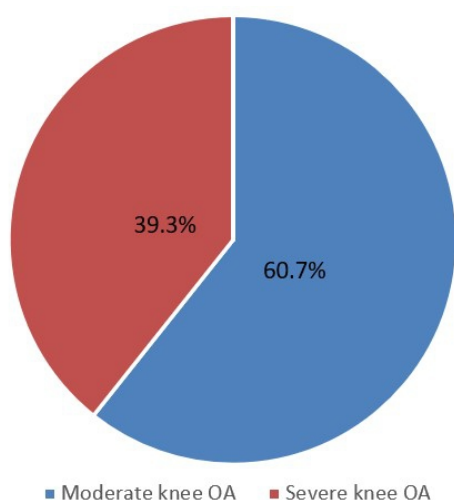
Pie chart showing the radiographic severity of knee OA.
